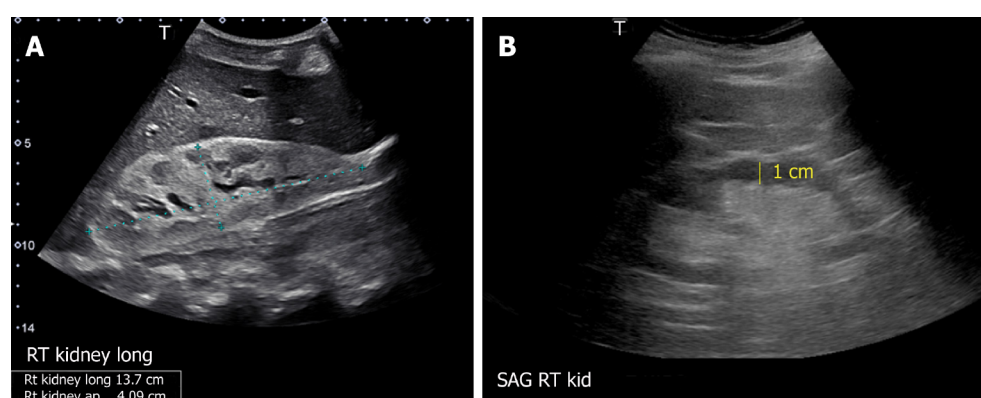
Renal sonogram demonstrating (A) large hyperechogenic kidney in a patient with multiple myeloma and (B) thin parenchyma approximately 1 cm in a patient with chronic kidney disease (normal parenchymal thickness: 1.5-2 cm). Citation: Koratala A, Bhattacharya D, Kazory A. Point of care renal ultrasonography for the busy nephrologist: A pictorial review. *World J Nephrol* 2019; 8: 44-58. Copyright© The Author(s) 2019. Published by Baishideng Publishing Group Inc. (corresponding author's prior open access publication).
